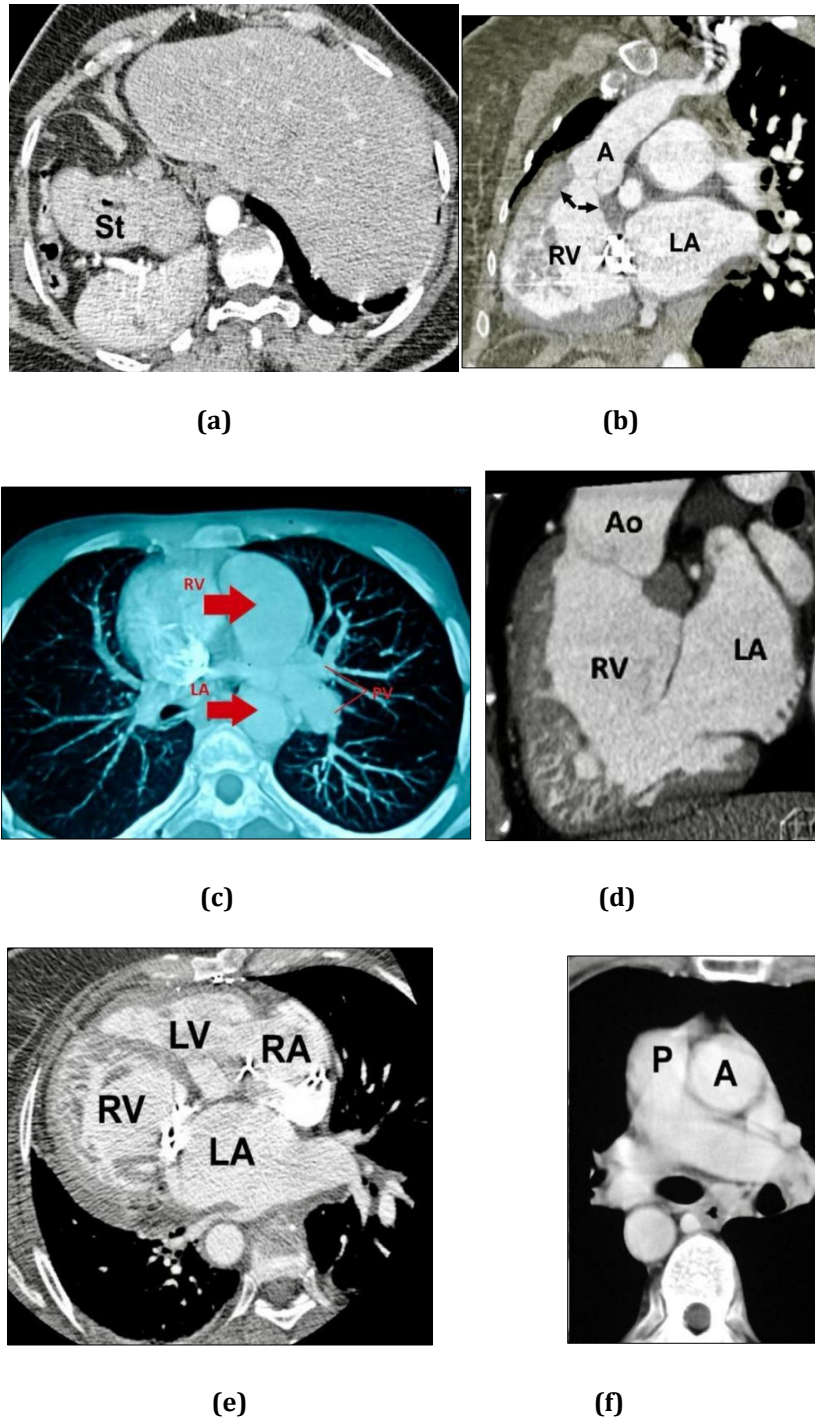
Cardiac CT imaging - Sequential segmental approach for the diagnosis of dextrocardia, situs inversus, and congenitally corrected transposition of great arteries (TGA). (a) Axial image through upper abdomen shows liver on left and spleen and stomach (st) on right, consistent with situs inversus. (b) Dextrocardia, situs inversus, and congenitally corrected transposition of great arteries (TGA). Reformatted oblique coronal image through outflow tract of posterior ventricle shows muscular infundibulum (arrows) separating inflow and outflow regions and confirming that posterior ventricle is a morphologic right ventricle. Ventricle connects to aorta (A). (c) CT scan of the patient showing discordant positioning of LA and RV. (d) Enhanced sagittal chest CT indicate the discordance between the atrioventricular and ventriculoarterial connections. The right ventricle endocardium is crude and triangular in shape. (e) Axial image at level of cardiac chambers shows that morphologic left atrium (LA) is connected to a morphologic right ventricle (RV), distinguished by prominent trabeculations along its septal surface. Morphologic right atrium (RA) is connected to a morphologic left ventricle. (f) Shows that main pulmonary artery (P) is to right of ascending aorta (A), an inverted relationship, as is expected with situs inversus. PV, Pulmonary vein; LA, left atrium; RV, right ventricle. Ao, aorta; LV, left ventricle; PA, pulmonary artery
